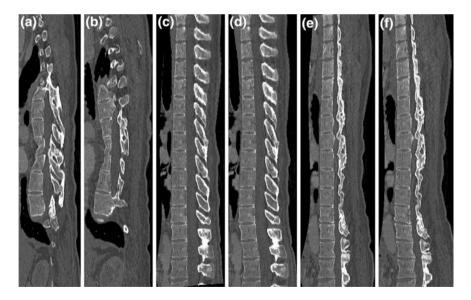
A sagittal cross-section of a 3D CT image of a scoliotic spine, obtained by a orthogonal MPR, b oblique MPR, c orthogonal CPR (with anatomical deformations), d orthogonal CPR (without anatomical deformations), e oblique CPR (with anatomical deformations) and f oblique CPR (without anatomical deformations)
